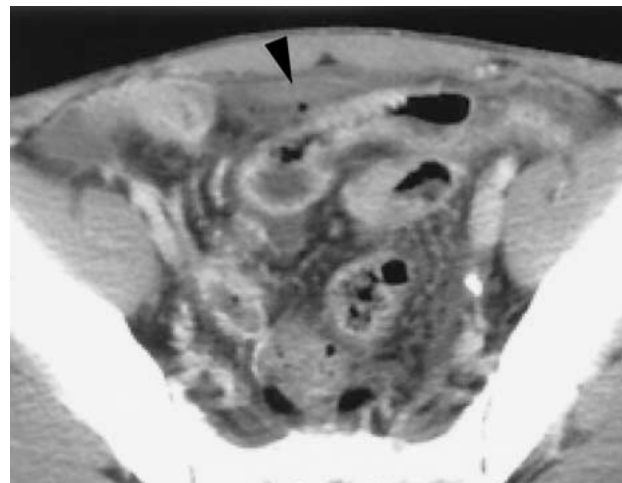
Contrast-enhanced CT image of an ileal perforation in a patient with Crohn disease. An air bubble is seen adjacent to the perforated ileal loop (*arrowhead*).
